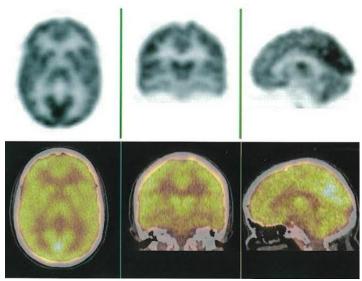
¹⁸FDG PET/CT of the endocranium, physiological distribution FDG. Top line PET scans, bottom line fused PET/CT scans. From the book Nuclear Medicine, Faculty of Medicine, Belgrade 2020.
